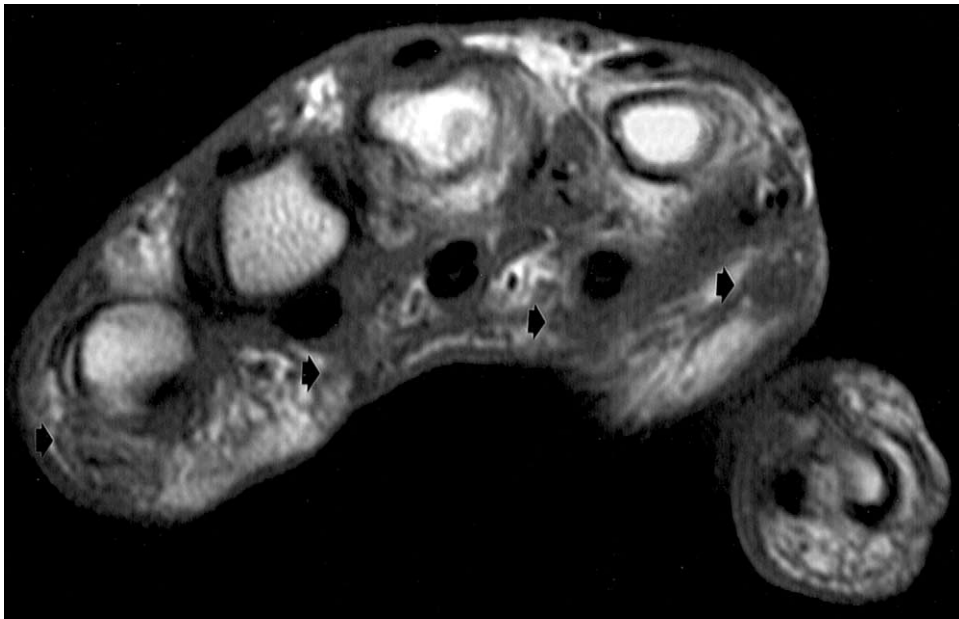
Axial T1-weighted images of the hand of patient 1 showed an ill-defined area of low signal intensity within the subcutaneous tissues of the palmar aspect of the hand and digits (black arrows) consistent with diffuse fibromatosis. This abnormal signal extends to involve the flexor tendons as they course through this region.
